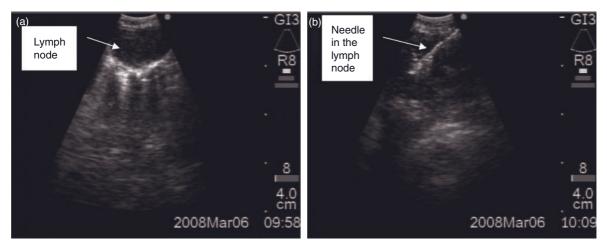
Endobronchial ultrasound monitor. The basic settings and format is shown here. Detailed set up is discussed in Chapter 1.
